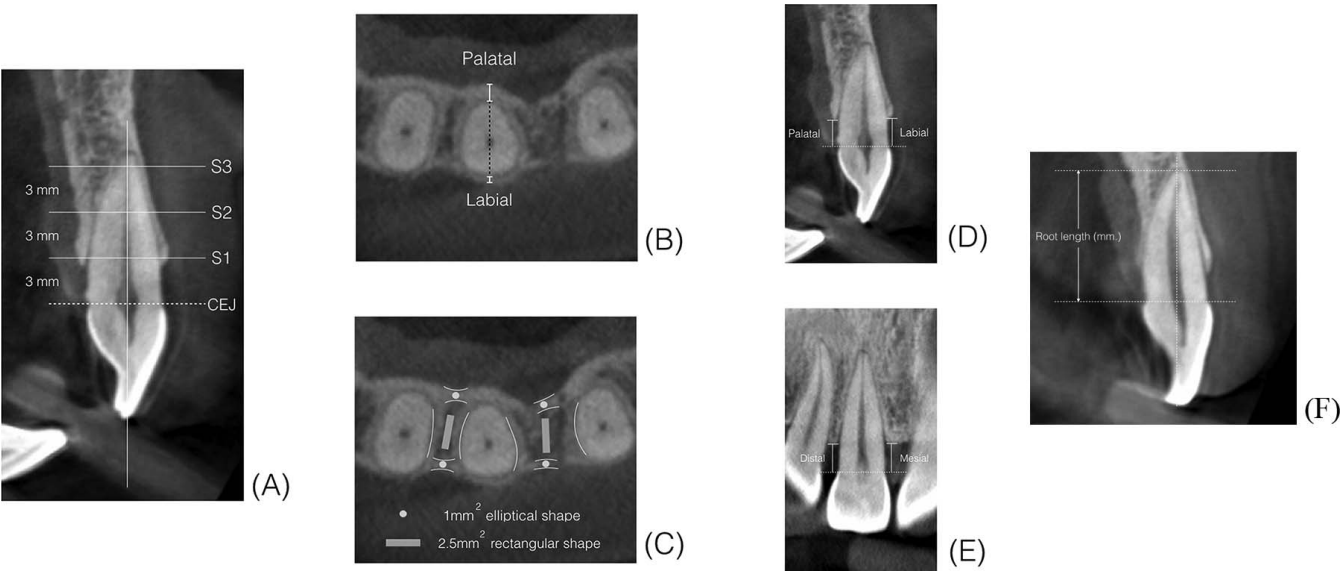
Measurement of (A) bone thickness and density at three levels, (B) bone thickness, (C) cortical and trabecular bone density, (D,E) bone height, and (F) root length on CBCT images.
